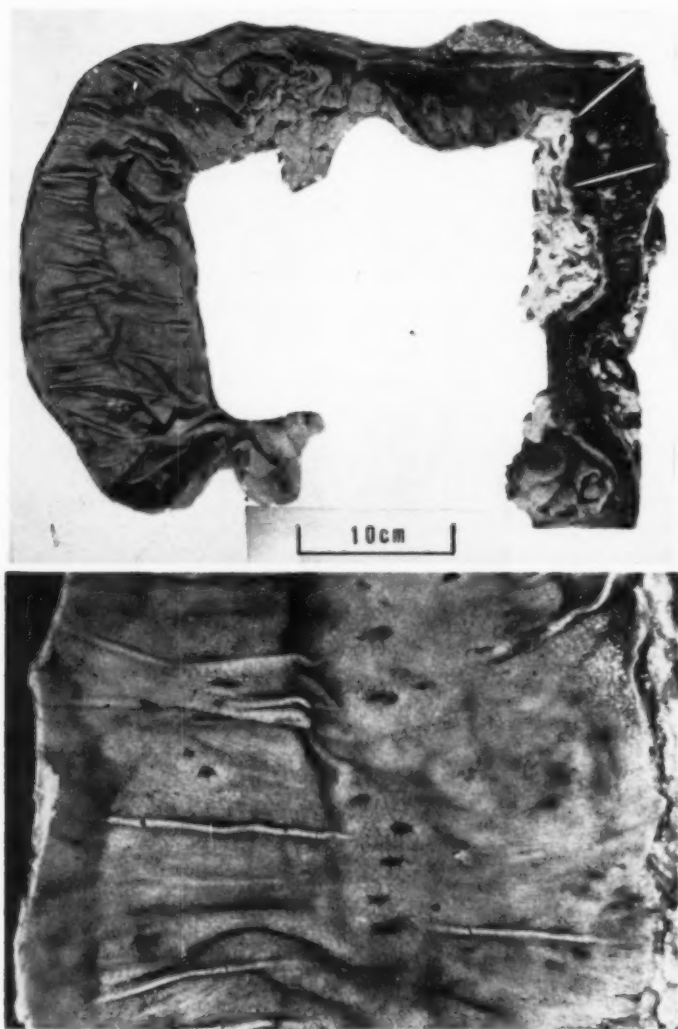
(a) The colon from a case in which the X-ray and operative findings were those of a left-sided colitis.
